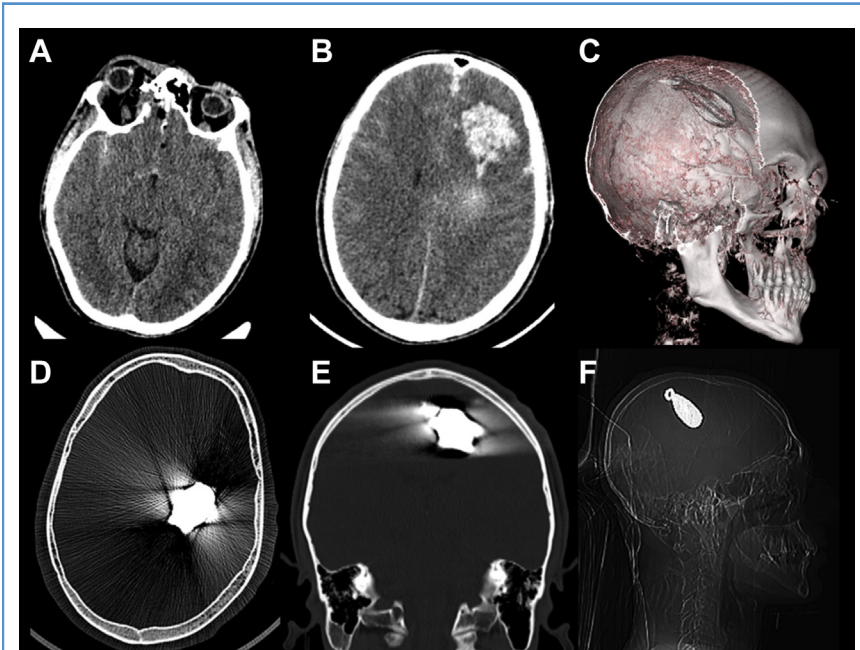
(A) Brain computed tomography (CT) image shows right medial orbital wall bone defect in the axial plane. (B) Brain CT image shows left intracerebral hematoma in the axial plane. (C) Reconstructed brain CT image shows the shape of fishing sinker and initial position. (D) Brain CT image shows metallic artifact of fishing sinker in the axial plane, bone window. (E) Brain CT image shows metallic artifact of fishing sinker in the coronal plane, bone window. (F) Lateral-view roentgenograph shows the initial position of the intracranial fishing sinker.
